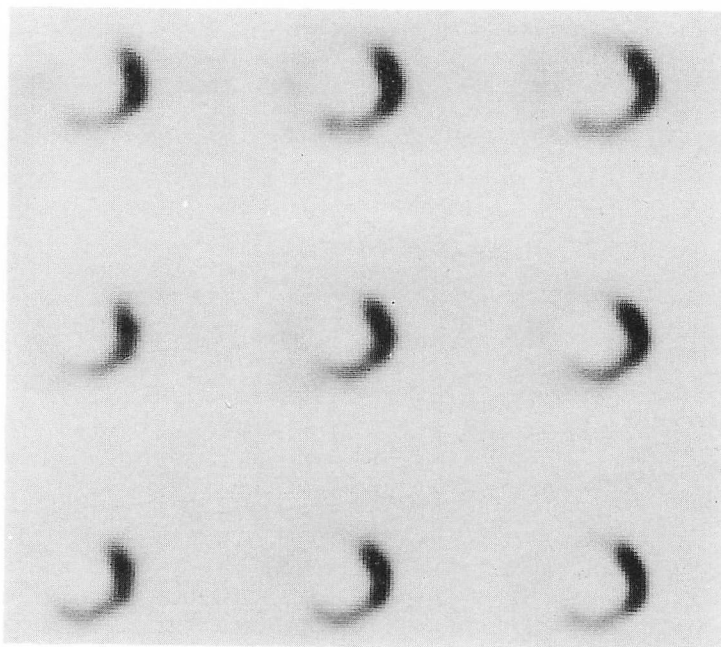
Three representative short-axis slices of stress (top), delayed (middle) and reinjection (bottom) thallium-201 SPECT images of a patient with anterior wall myocardial infarction.
